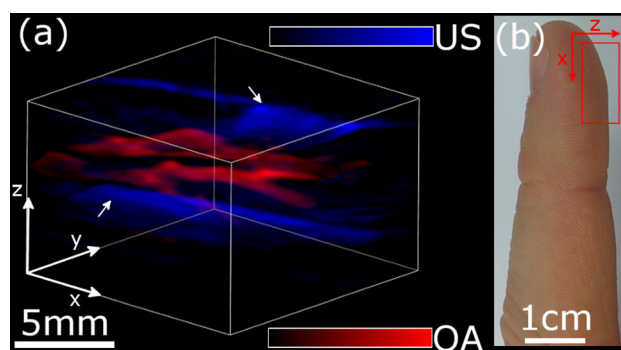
Hybrid imaging of finger in a healthy volunteer. (a) Three dimensional views of the optoacoustic and ultrasound reconstructions are displayed in red and blue, respectively. The ultrasound image allows visualizing the location of the skin and the bone surface (labelled by white arrows) while optoacoustic signals mainly convey contrast of the blood vessels. The imaged region in the finger is shown in (b).
